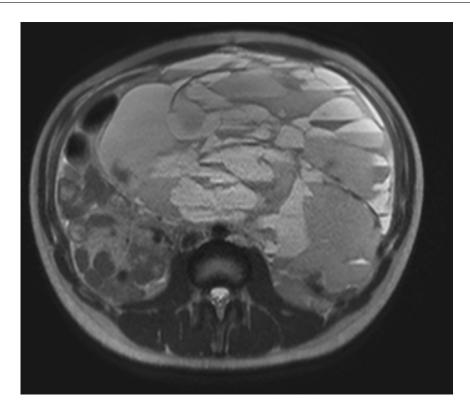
T2-weighted imaging MRI of the abdomen in this patient with undifferentiated embryonal sarcoma of the liver demonstrating multiple fluid levels.
